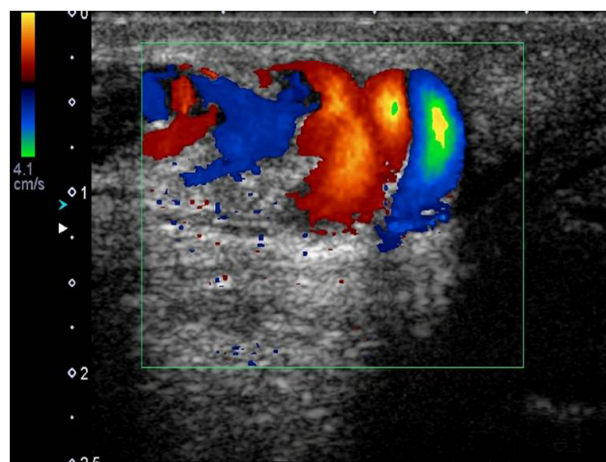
Color and spectral Doppler images show reversed flow during the Valsalva maneuver on left sided varicocele in a 25-year-old patient with ankylosing spondylitis.
